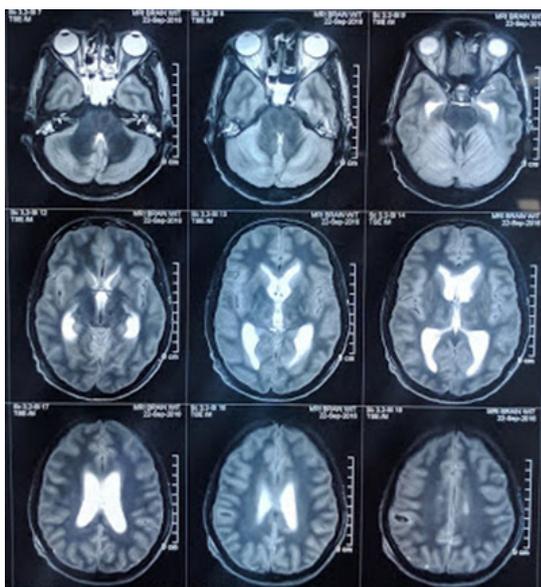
MRI Brain showing micro bleeds and midbrain hypoxic change.
